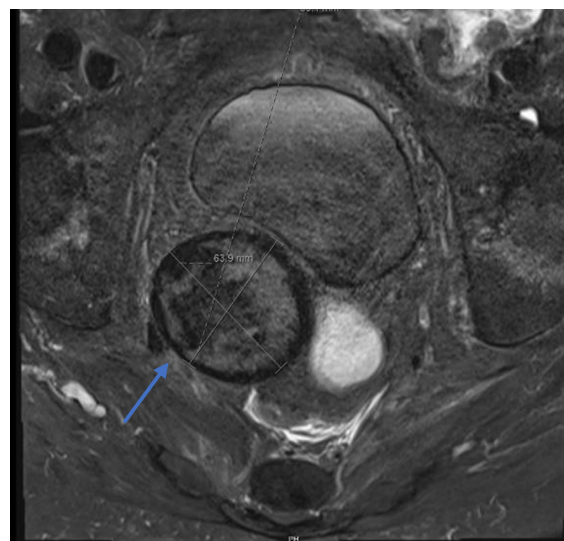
T1 Axial STIR. MRI of pelvis without contrast showed right internal iliac artery aneurysm measuring 10.6 cm craniocaudal dimension and 6.5 x 6 cm transverse dimension (arrow).
